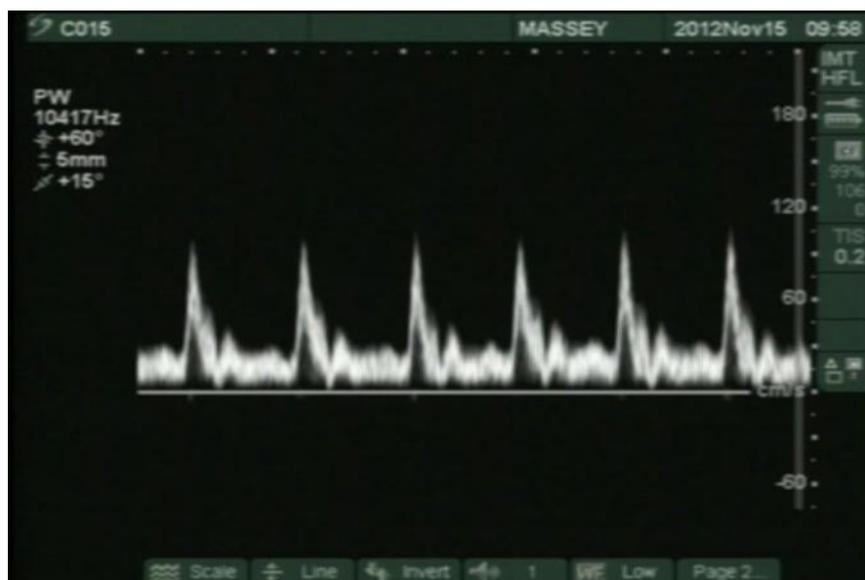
Doppler Spectral Trace over a 4.8 s period.
